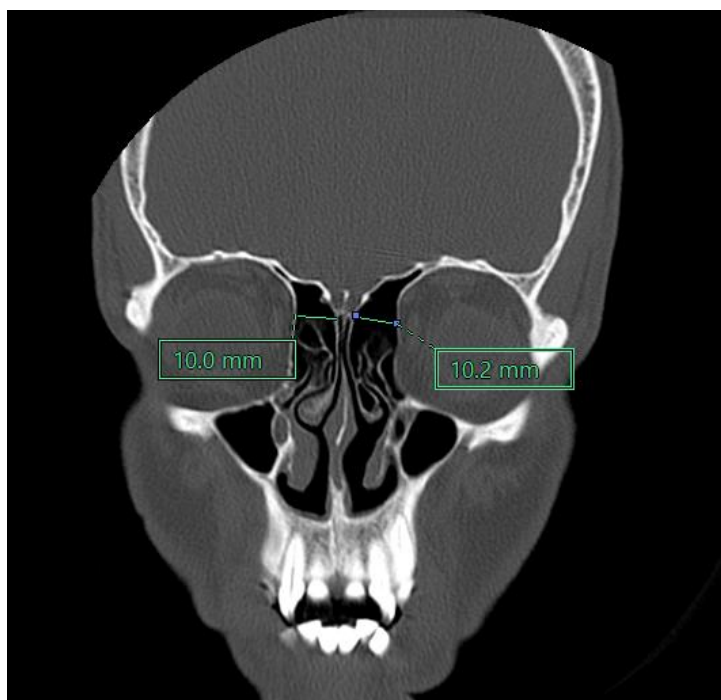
CT (CORONAL SECTION) WITH ETHMOID WIDTH MEASUREMENT
